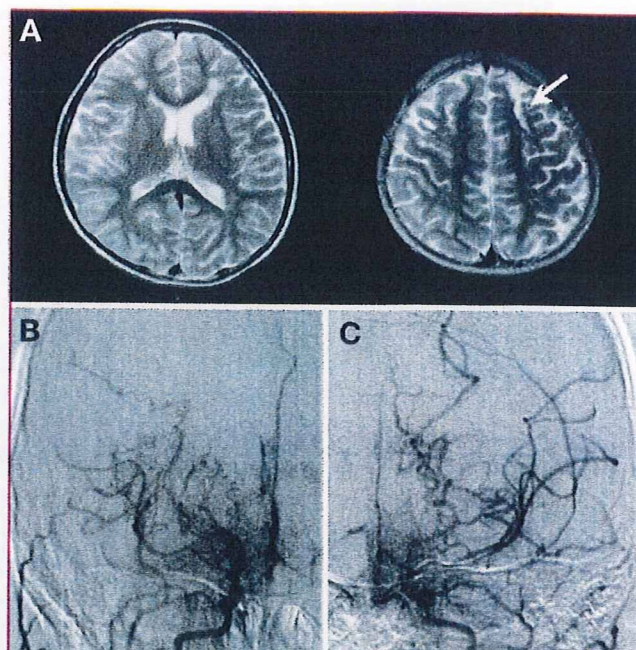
Preoperative radiological findings of an 8-year-old girl who developed transient weakness of the right extremities. A, T2-weighted magnetic resonance imaging shows cortical infarction in the left frontal lobe (arrow). A small infarction can be seen in the deep white matter of the bilateral frontal lobes. Towne's views of right (B) and left internal carotid angiograms (C) demonstrate typical findings of moyamoya disease, ie, severe stenosis of the terminal portion of the internal carotid artery and marked development of moyamoya vessels on both sides.
